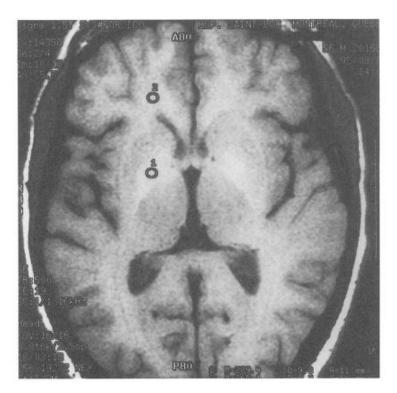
Pallidal hyperintensity on T₁-weighted MR image from a cirrhotic patient. Pallidal index calculated as the ratio of globus pallidus (1) to subcortical frontal white-matter (2) intensity was 133 (normal range: 96 - 103).
